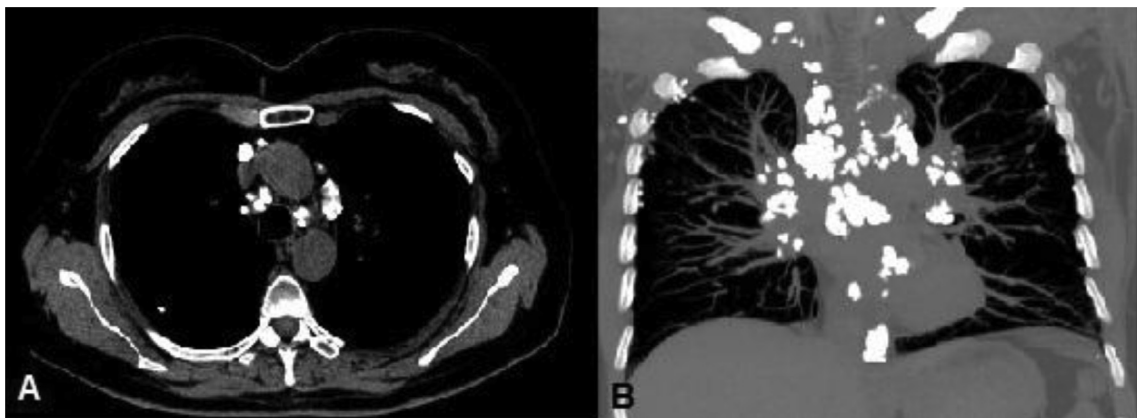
CT images from a 55-year-old woman presenting with chronic cough, fever, and weight loss. Axial reconstruction of images obtained in the aortopulmonary window shows calcified lymph nodes with diameters >1.2 cm(A), best demonstrated on maximum-intensity projection(B). A lymph node biopsy revealed histoplasmosis.
